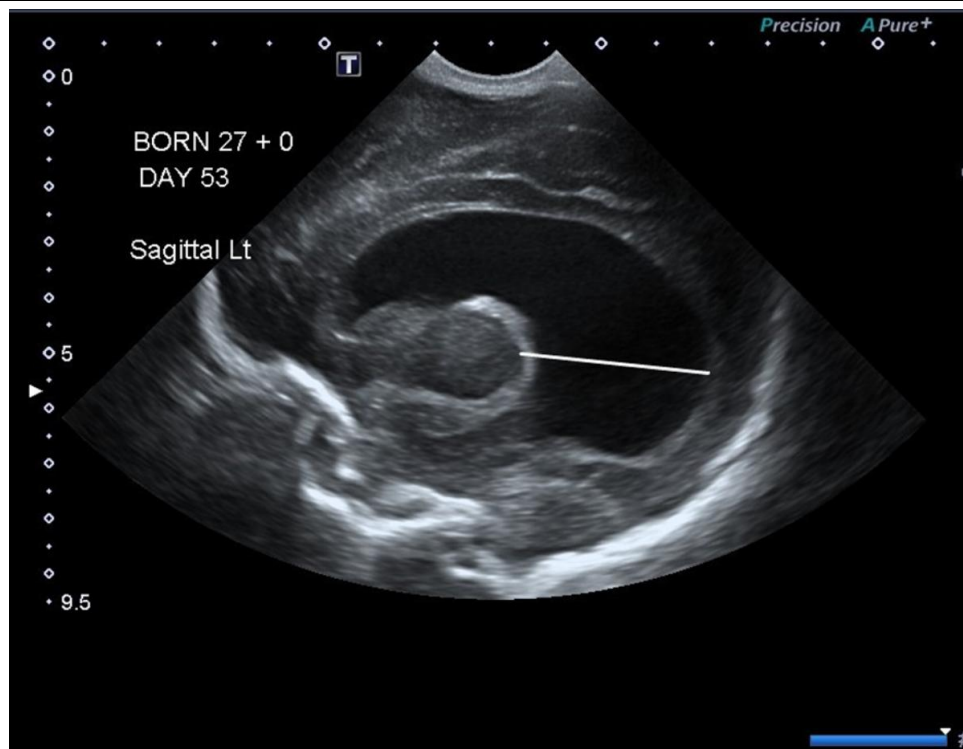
Ultrasound scan in the para sagittal plane showing the thalamo-occipital distance (TOD)
